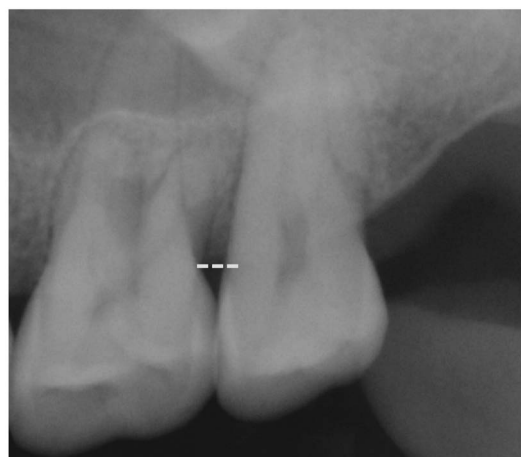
Radiographic view at 3 months later after treatment. It shows the healing state of the interproximal bone. The bone height may be slightly different depending on the radiographic angle. In Fig 2a and 2b, the improvement of bone height was evaluated by the ridge line of the interdental septum paralleling the line between the cement-enamel border of adjacent teeth.
